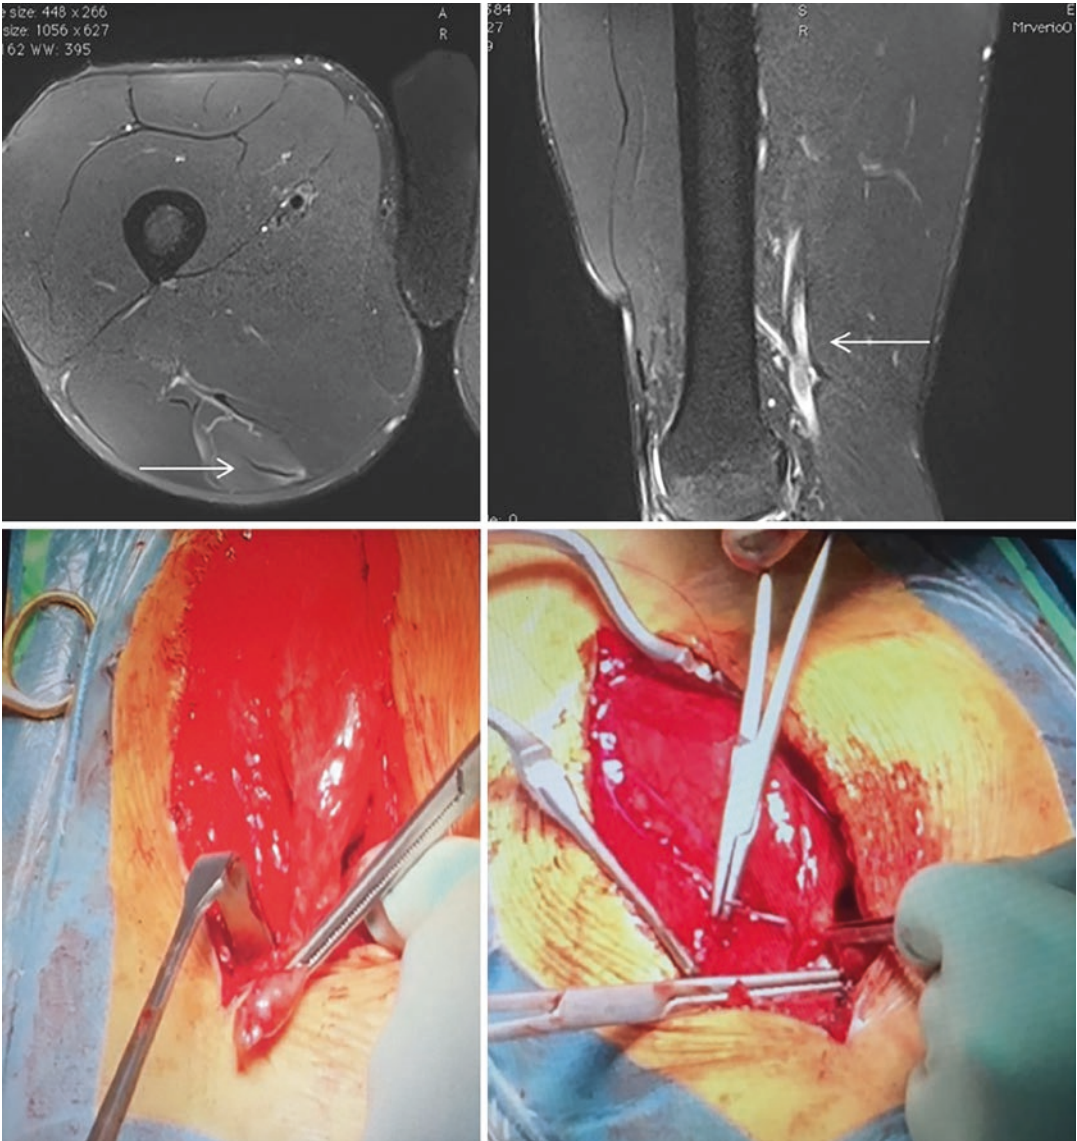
MRI of distal hamstring injury (*white arrow*). Intraoperative views of semitendinosus distal rupture sutured to the adjacent semimembranosus distal tendon, in professional football player
